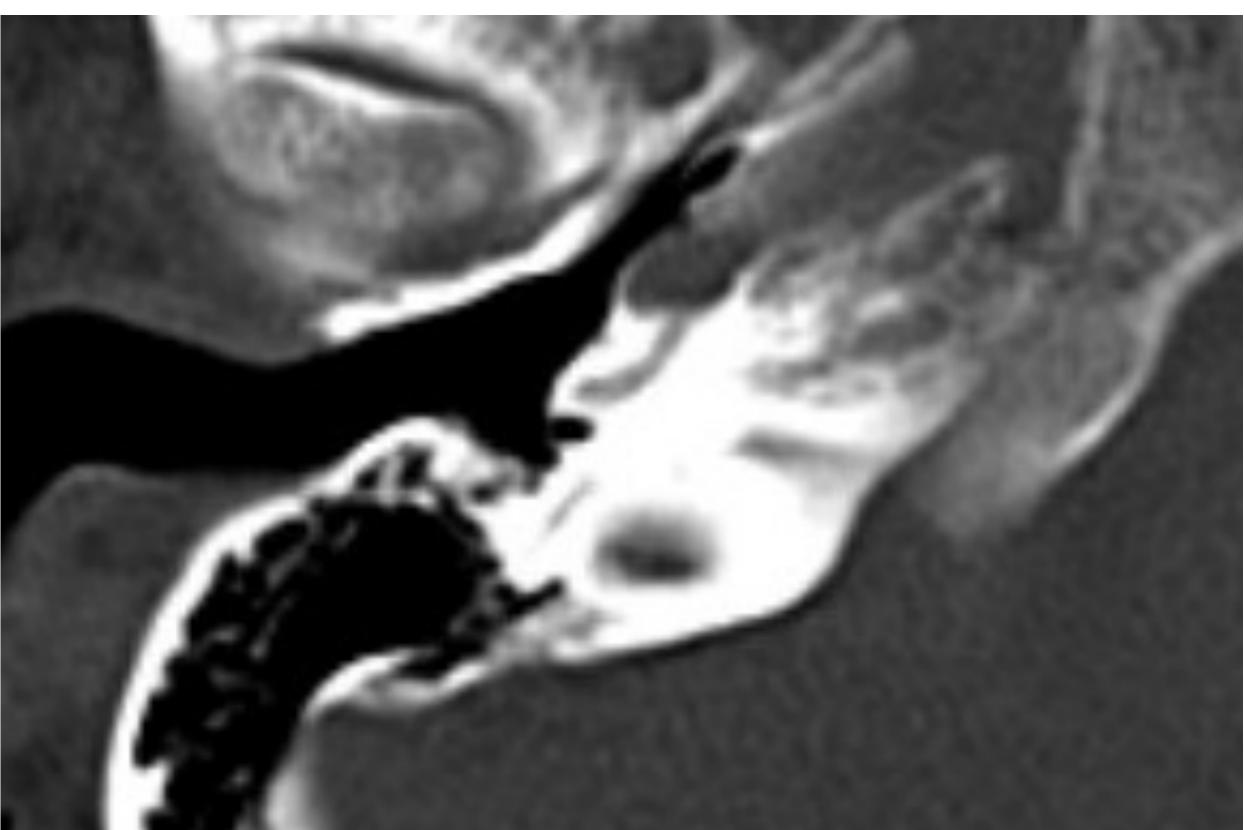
CTA Axial Right Cochlea
